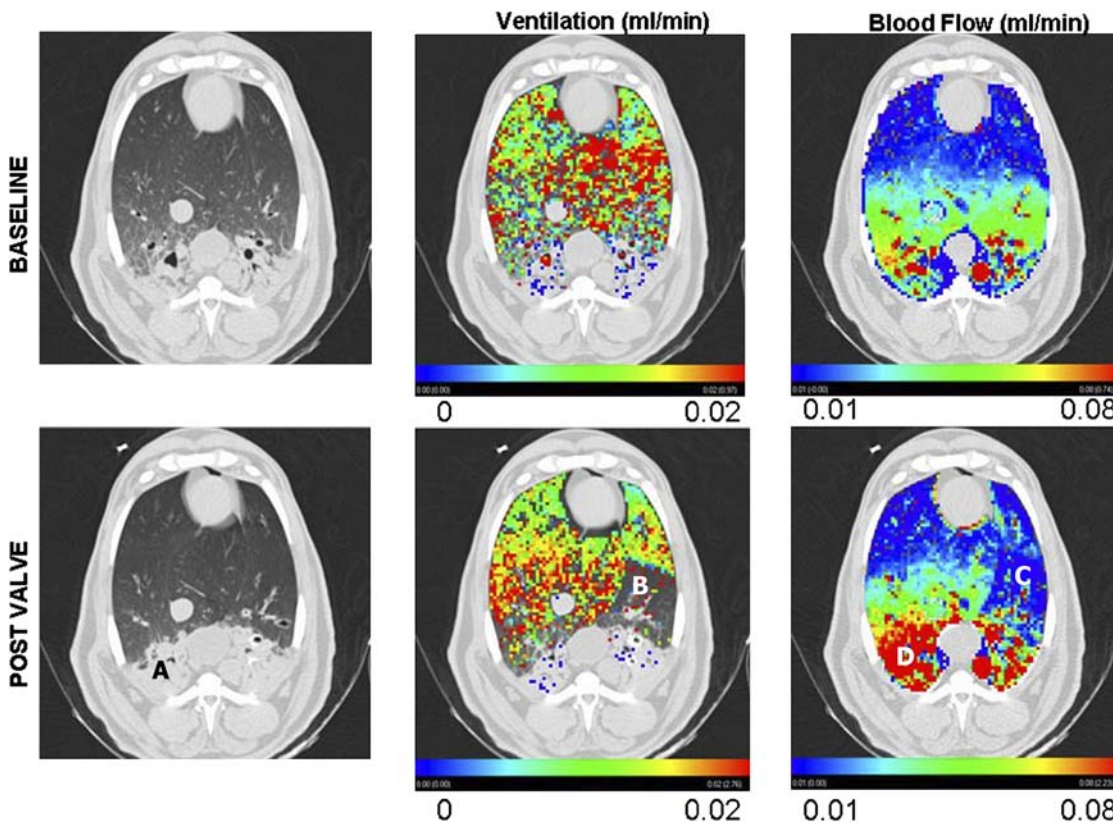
Before (baseline; top row) and after (post valve; bottom row) endobronchial valve placement. The left column provides a view of one CT section at the level of the diaphragm dome. Note the significant dependent pneumonia (A). The center column demonstrates ventilation overlaid in color as assessed by xenon-CT. Note that there is little ventilation in either the baseline or the post valve in the region of the dependent pneumonia. By design, there is a large region where ventilation was eliminated by the valve placement (B). The right column shows a color overlay of the perfusion measurements. Note that in the region (C) coinciding with region B from the central column (no ventilation due to valve placement), there
